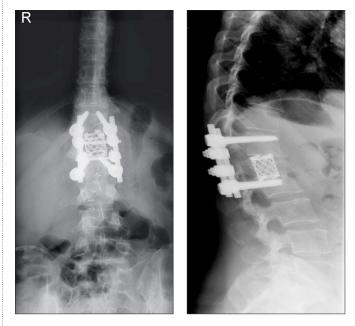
Post-operative antero-posterior and lateral x-ray of lumbar spine showing the anterior mesh interbody cage and the posterior stabilisation of the L1 vertebra.
